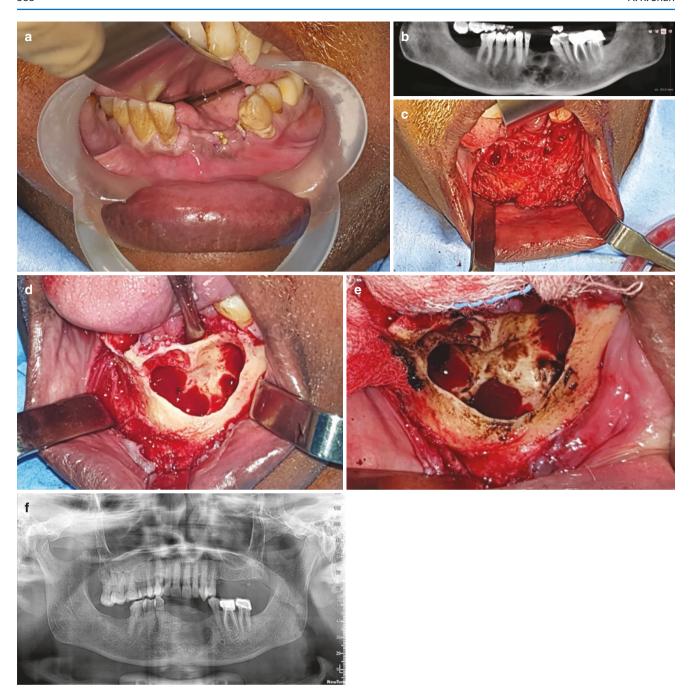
(a) loosening of teeth and expansion of the gums in the anterior lower mandible. (b) A OPG and CBCT showing multilocular radiolucency in the anterior mandible. (c) Lesion exposed (d) lesion excised and peripheral ostectomy done (e) carnoys solution applied to surgical bed (f) sixteen month post operative OPG
